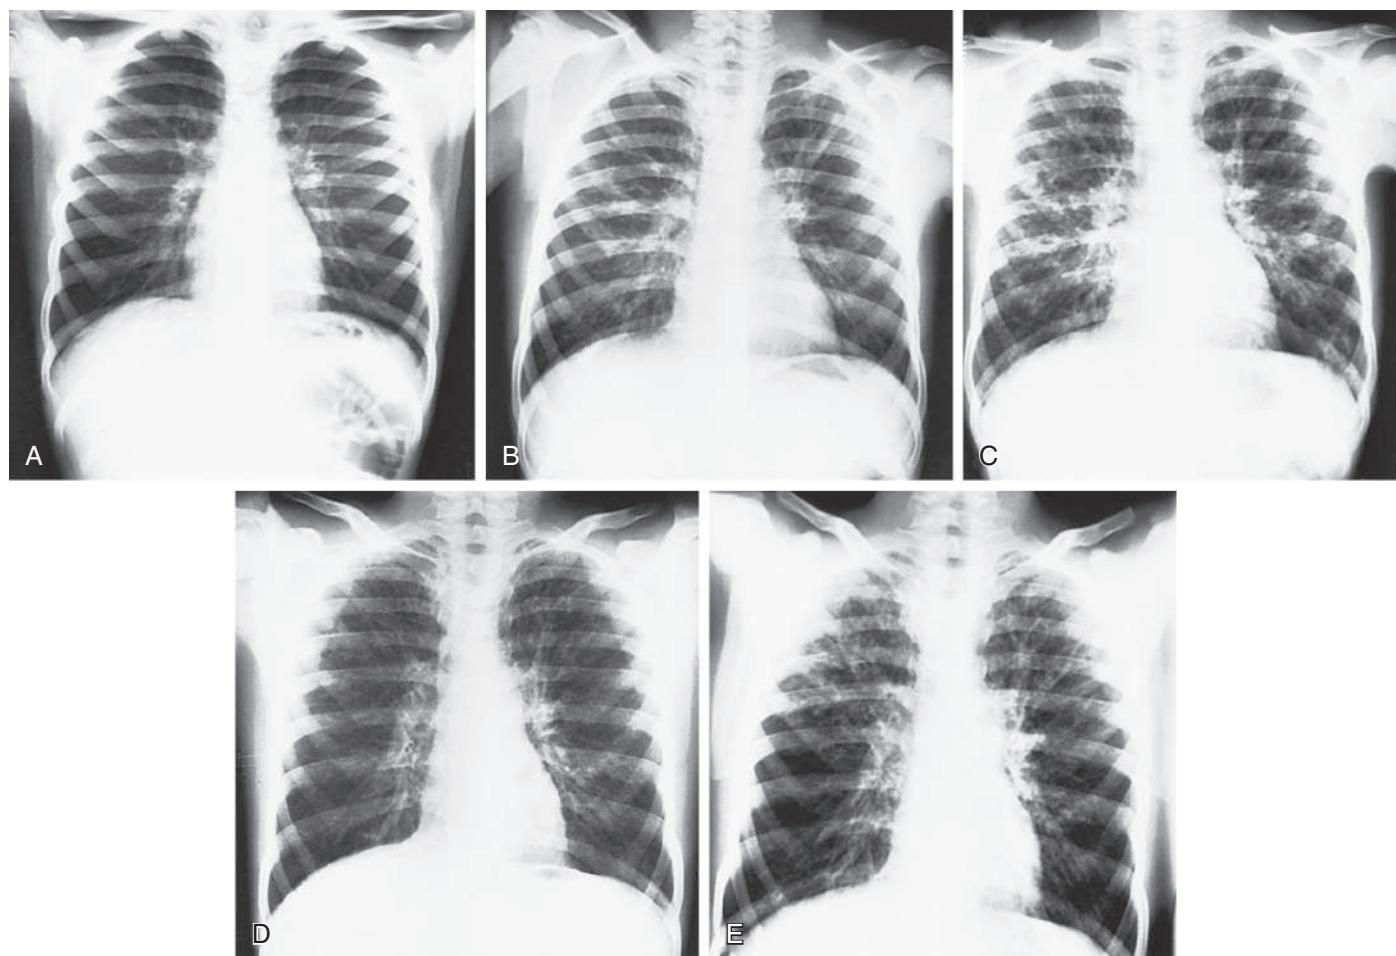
Serial radiographs in a child show the changing appearance of cystic fibrosis over 6 yr. A, At 9 yr, frontal radiograph shows minimal peribronchial thickening and hyperaerated lungs indistinguishable from asthma. B, Nineteen mo later, the radiographic picture has worsened considerably. Extensive peribronchial thickening is now noted. Mucoid impaction of the bronchus is seen in the left upper lobe, and hilar shadows have become abnormally prominent. C, Ten mo later, further deterioration is obvious. Widespread typical changes of cystic fibrosis (CF) are noted throughout both lungs. D, Follow-up studies show considerable improvement, which suggested that some of the changes evident on (C) were from superimposed infection. E, One yr later, note the progressive changes of CF—most severe in the upper lobes bilaterally. (From Long FR, Druhan SM, Kuhn JP. Diseases of the bronchi and pulmonary aeration. In Slovis T, ed. Caffey's Pediatric Diagnostic Imaging, 11th ed. Philadelphia: Mosby; 2008: Fig. 73-54.)
